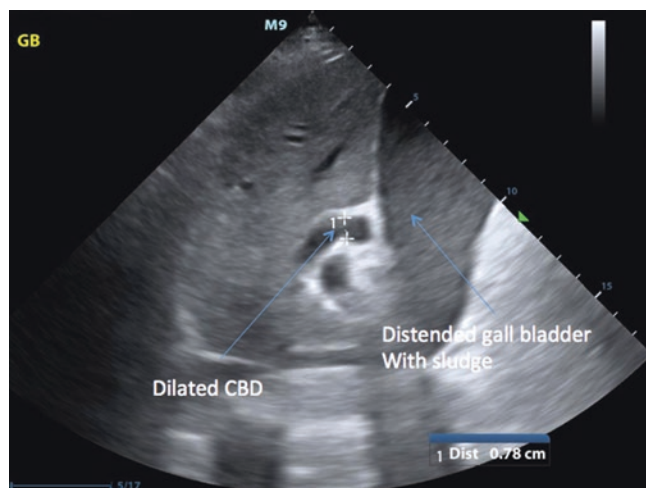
Bedside ultrasound for suspected biliary disease. A distended gallbladder with extensive sludge is seen on this bedside ultrasound image. A distended common bile duct is also seen. See also Video 37.15
